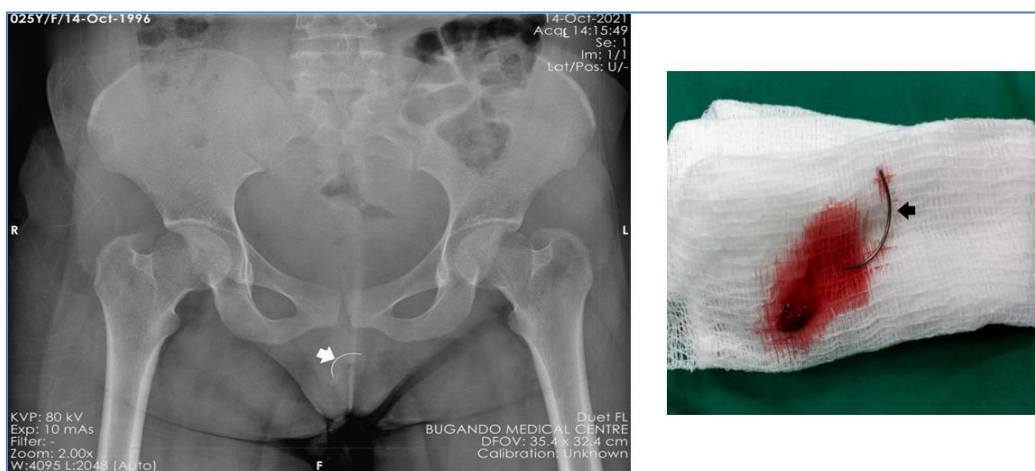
On the left, a Pelvic x-ray of Case 3 demonstrating an opaque curvilinear object (short solid white arrow) within the right paramidline perineal soft tissues in keeping with a retained needle. On the right, post procedural image of the retrieved needle (short solid black arrow).
